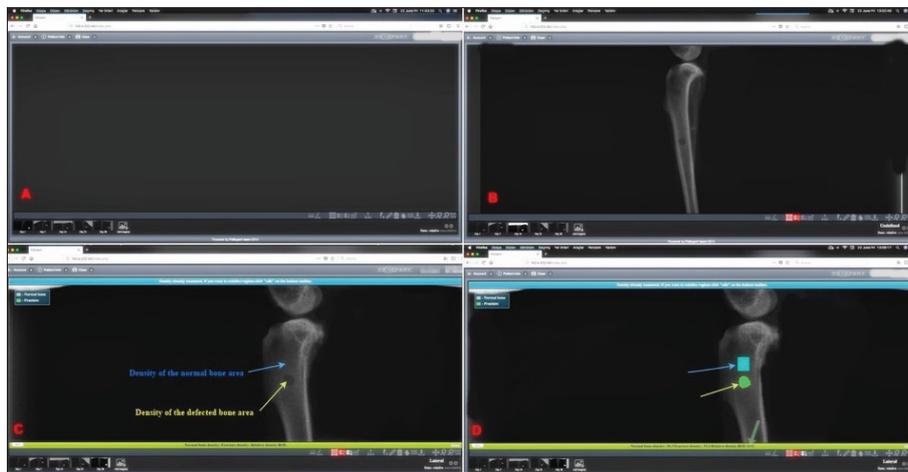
The Fx-Expert program was used to determine the relative optical density (ROD) value and the sequence of images showing the ROD analysis with the program. A: Accessing the program via the internet; B: Opening the X-ray image in the program; C: Displaying the solid and defect regions on the x-ray image; D: Measuring the OD values in the solid and defect regions, and the program calculating the ROD value automatically (green arrow)
